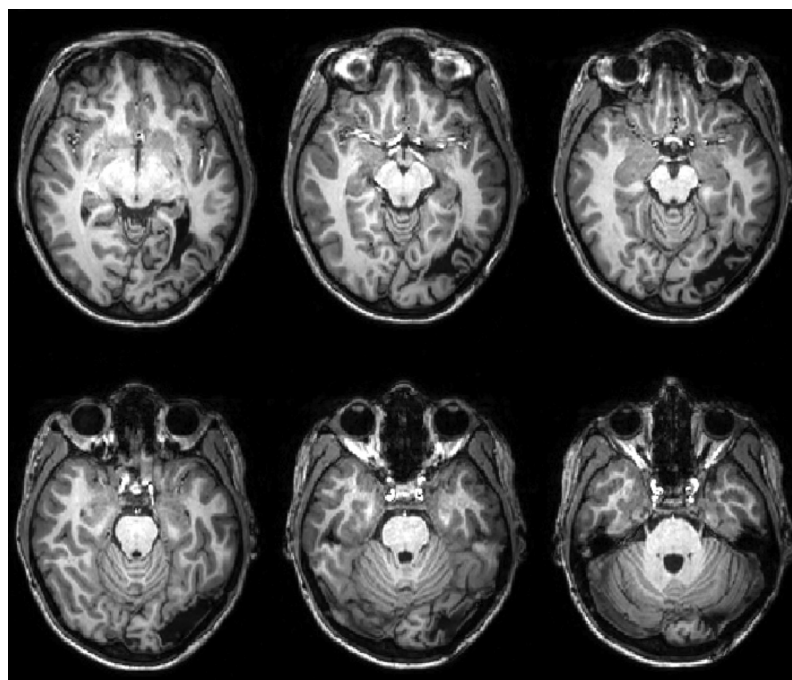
MRI-scan of LK's lesion in the left occipito-temporal cortex (see text for anatomical description).
